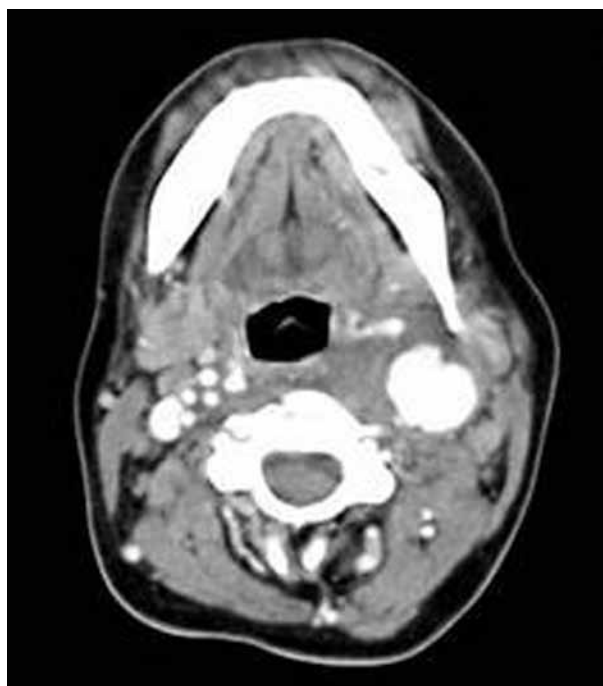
Computed tomography revealing pseudoaneurysm originating from the wall of left internal carotid artery.
